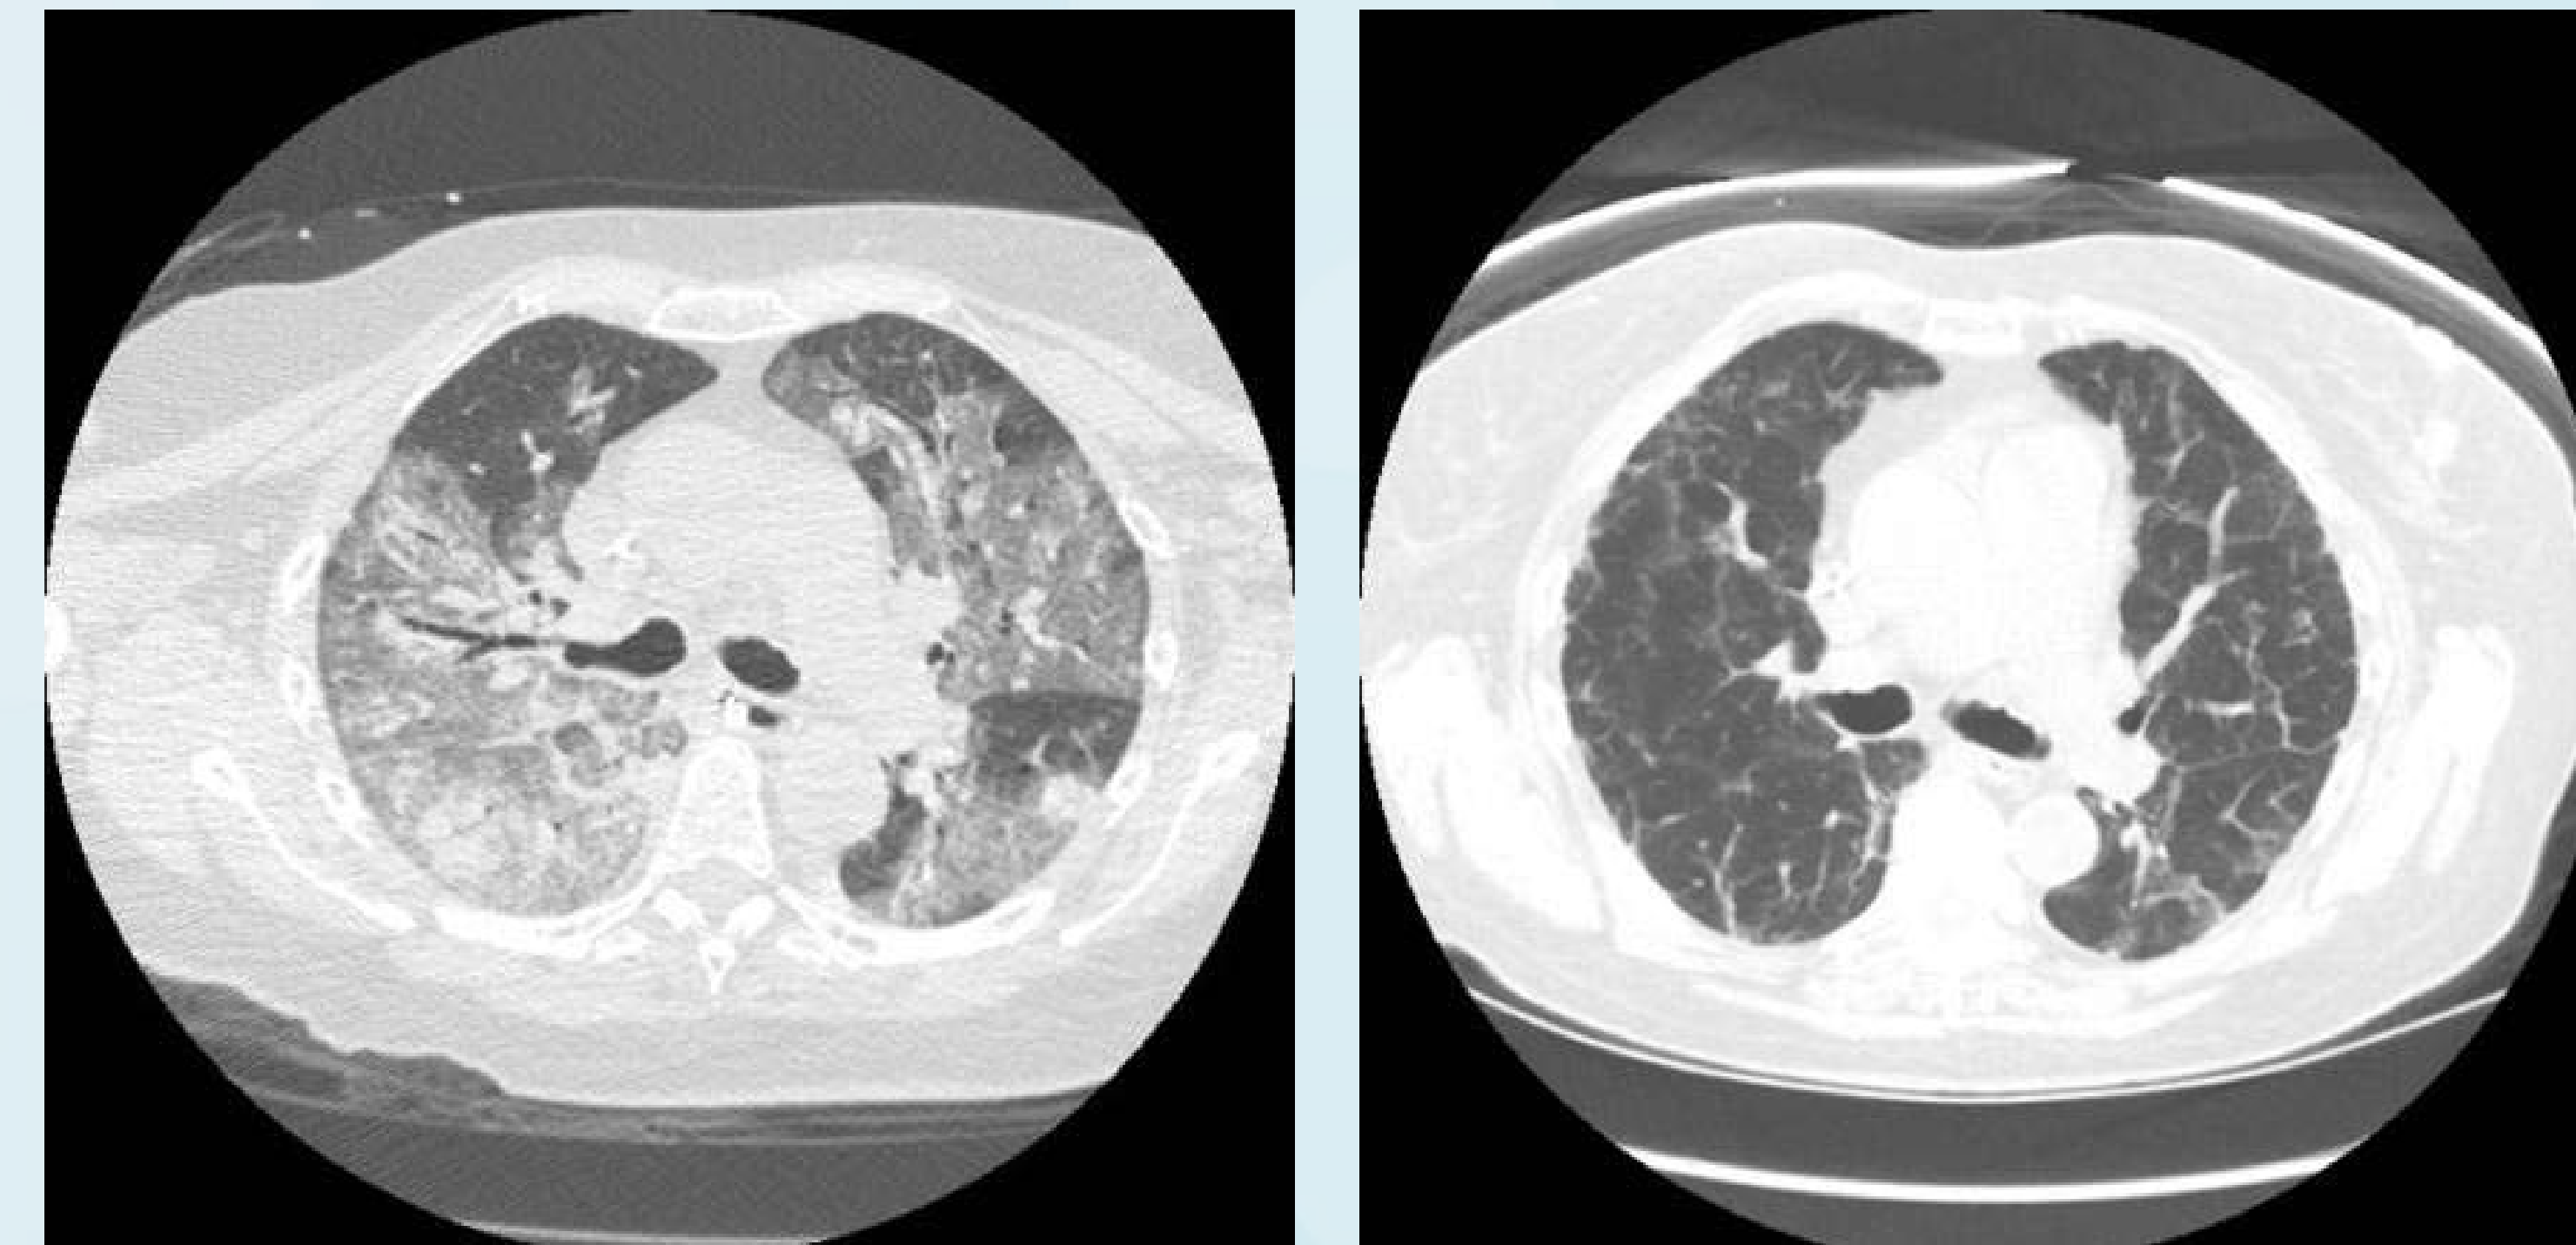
(Patient A) 62 year old female with Influenza A H1N1 and community acquired pneumonia initial CT scan on left side. The follow up chest CT scan 177 days post ECMO is on the right side.
